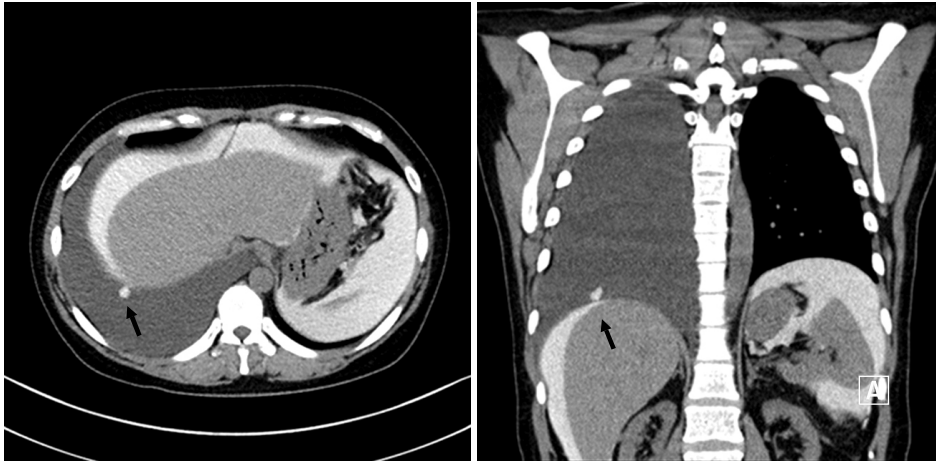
Chest computed tomography 1 hour after injection of radiocontrast medium into the peritoneal fluid.
